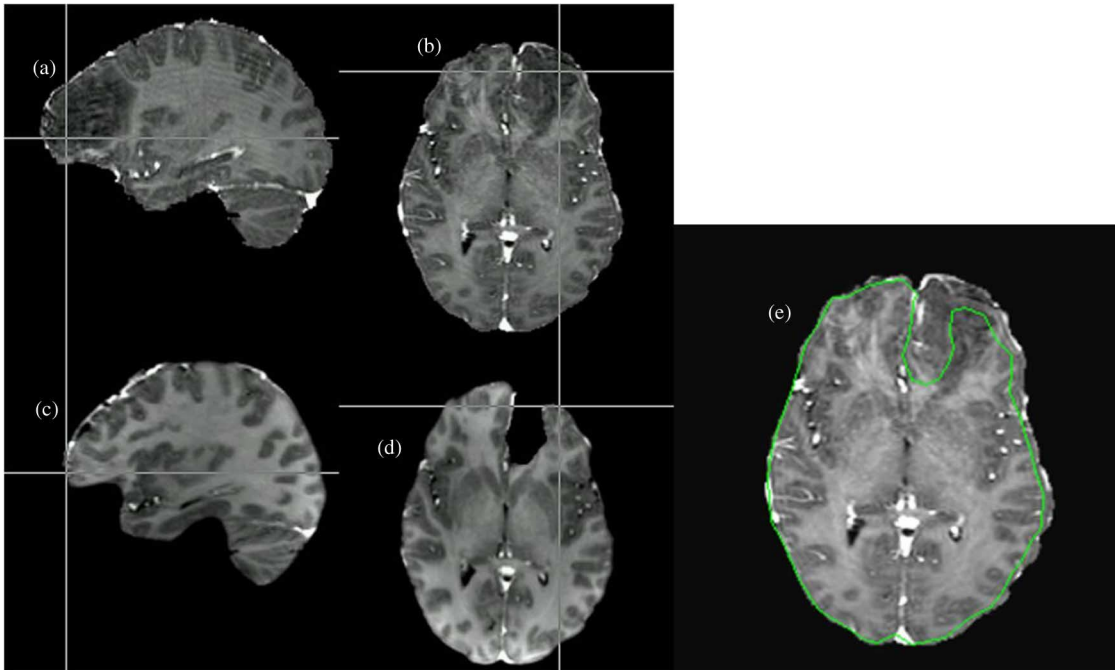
Qualitative representation of shift between pre-op and post-op MR images. (a) Sagittal slice of the patient's pre-op image. (b) Axial slice of the patient's pre-op image. (c) Corresponding sagittal slice of the patient's post-op image. (d) Corresponding axial slice of the patient's post-op image. Cross hairs in the bottom row represent a point picked on the cortical surface of the patient's post-op image that actually lie beneath the parenchyma in the patient's pre-op image due to the presence of brain shift. (e) Outer edge contour of an axial slice (shown in green) of the patient's post-op image overlaid on the patient's pre-op image.
